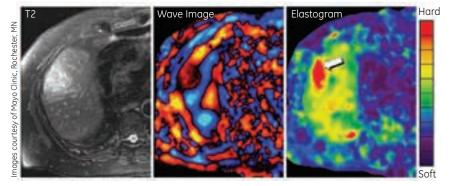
Left: Conventional MR image shows a mass in the liver. Center: Mechanical waves are imaged in the liver, using an MRE sequence. Right: The wave information is processed to generate an elastogram, which indicates that the mass (arrow) is very hard, consistent with a malignant tumor (hepatocellular carcinoma).
